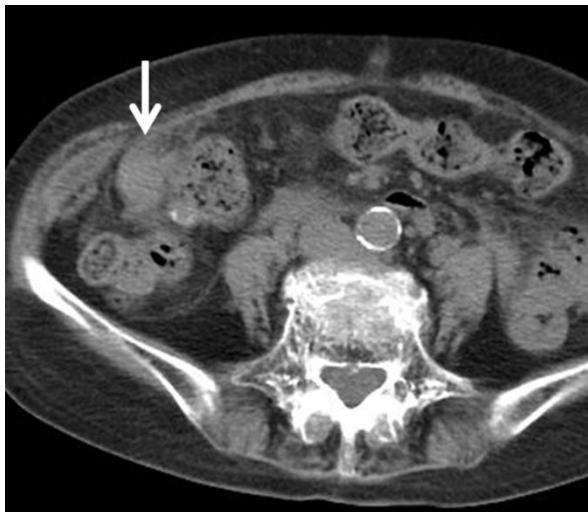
Abdominal computed tomography (CT); Unenhanced computed tomography (CT) imaging shows a peritoneal metastasis of hepatocellular carcinoma (HCC) measuring 25 mm in diameter adjacent to the ascending colon (white arrow).
